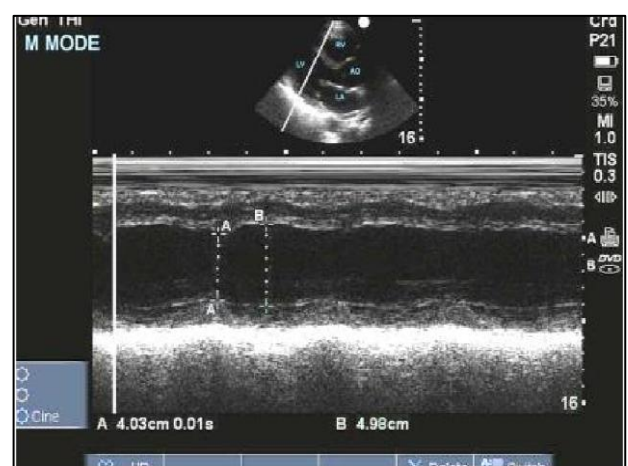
Evaluation of ejection fraction using M mode echocardiography. Distance A represents the end systolic diameter and distance B represents the end diastolic diameter. Ejection fraction by Teicholz method was 39.1% in this case (hypodynamic), seen in a case of cardiogenic shock in study.
